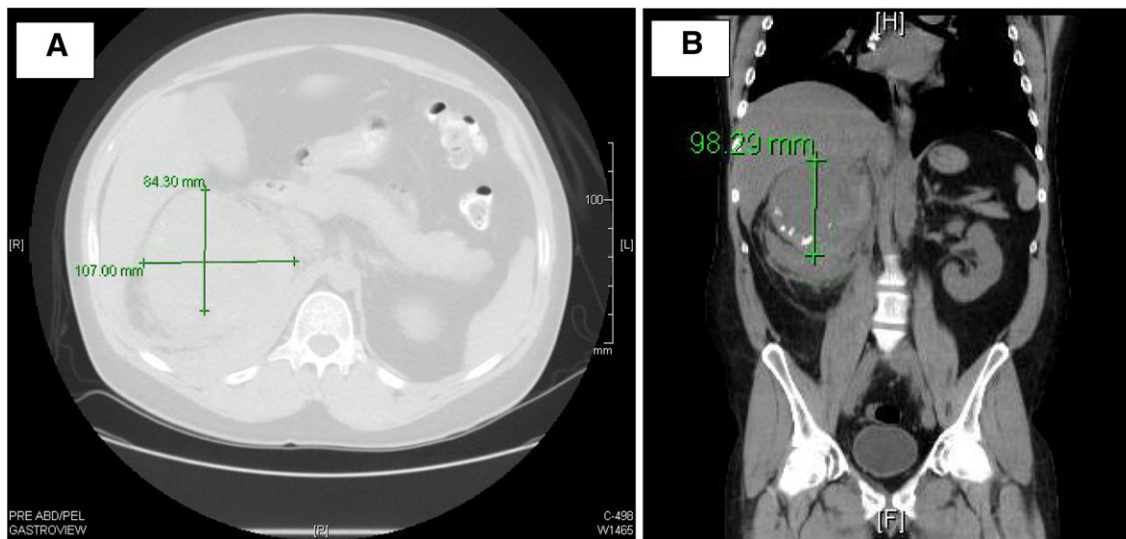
(A) Computed tomographic scan of the abdomen shows a right adrenal mass with hyperdensity centrally within the mass, indicating intratumoral hemorrhage. (B) Magnetic resonance imaging of the mass demonstrates peripheral calcifications.
